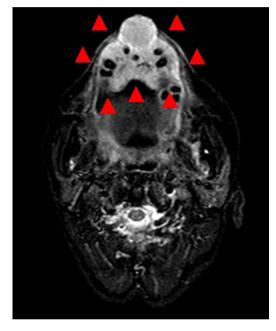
Preoperative MRI (STIR) shows a lesion in the anterior maxilla (arrows).
